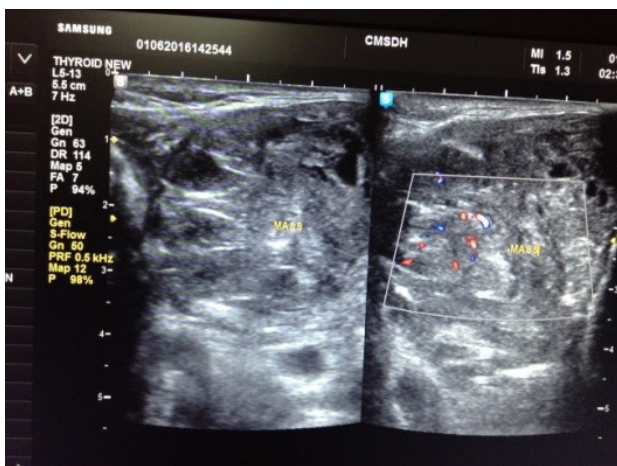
Grayscale and colour Doppler assessment of neck masses
